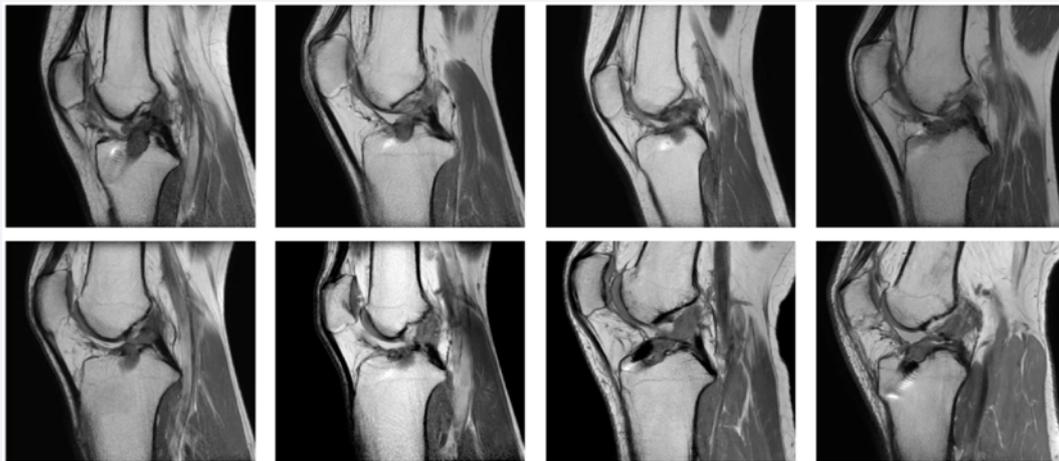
24 month MRI for patients having intact grafts at 36 months. MRI showed a thin ligament and persistent regional hyper-intensity; a small cyclops lesion was observed for one patient (top left image).
